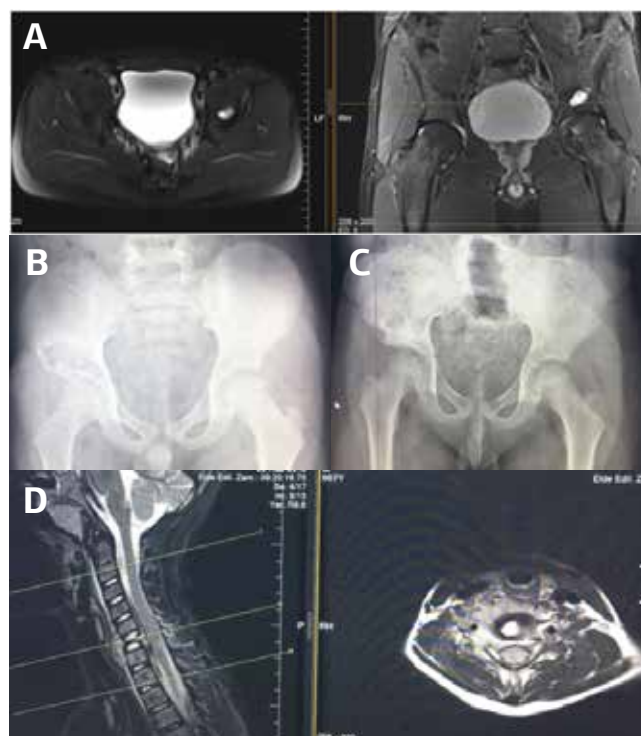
A 37-year-old male, left iliac wing 20x12x15 mm, central area hypointense, periphery mild hyperintense, a capsular cystic mass showing mild enhancement. A 6-year-old male, a mass lesion of 45x29 mm showing growth toward acetabulum ceiling in the right iliac bone (A). A direct X-ray on postoperatif month (B). The same patient developed vertebral plana on the 12th month of postoperative follow-up (C).
